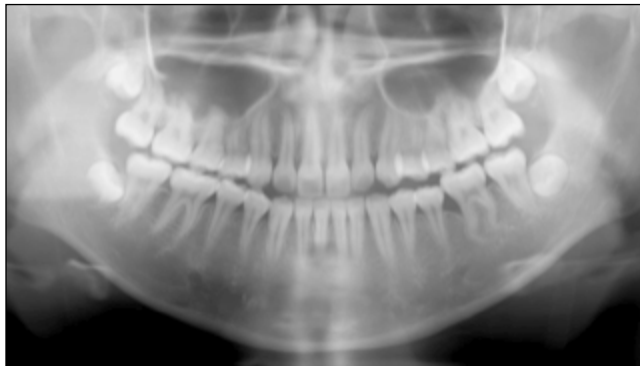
A panoramic radiograph obtained at 15 years and 5 months of age (7 years and 7 months after marsupialization; 4 years and 3 months after enucleation of the lesion).
